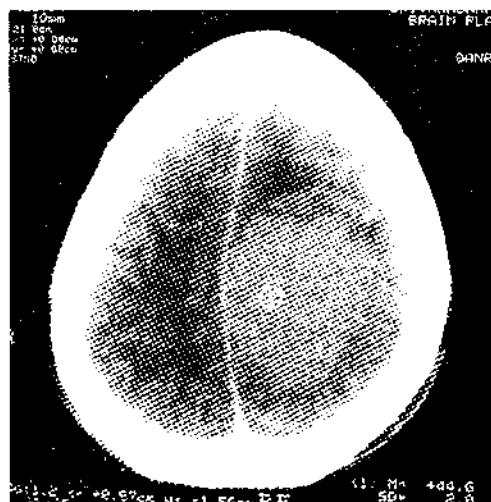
CT scan of a patient with left temporal glioma
